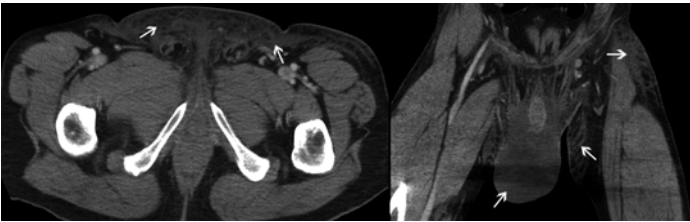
Axial and coronal CT images of Fournier's necrotizing fasciitis. Diffuse abdominal wall edema is again seen (*white arrows*), primarily involving the scrotum. Although subcutaneous air is sensitive for fasciitis, as in this case it is not always present. In contrast to prior patient, the clinical presentation here was that of sepsis secondary to pelvic infection.
